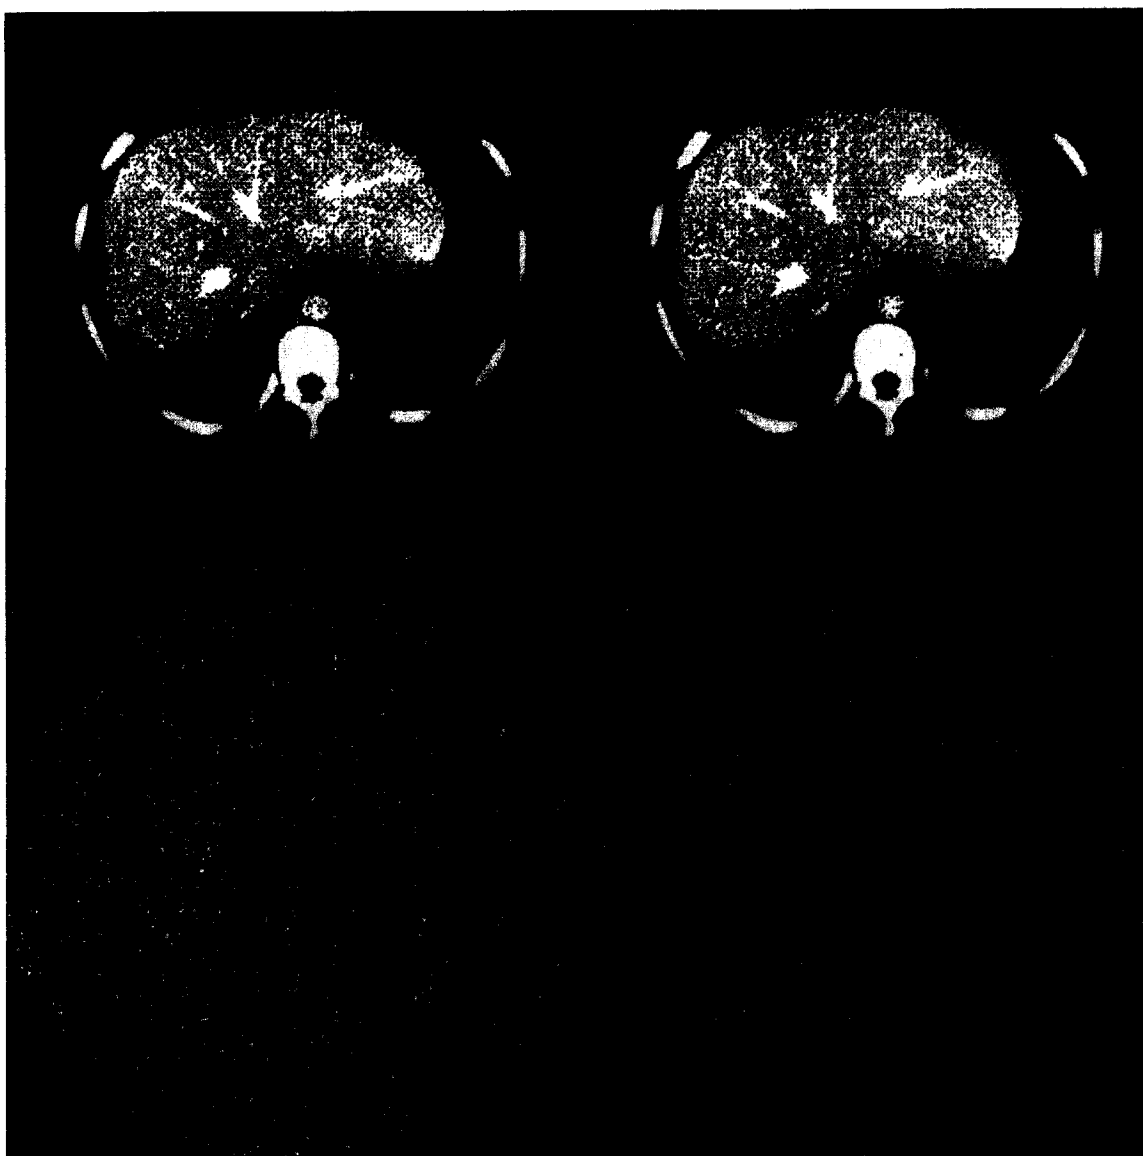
Original CT image (top, left), CT image wavelet compressed 10:1 (top, right), absolute difference image (bottom, left), and signed difference image (bottom, right).
